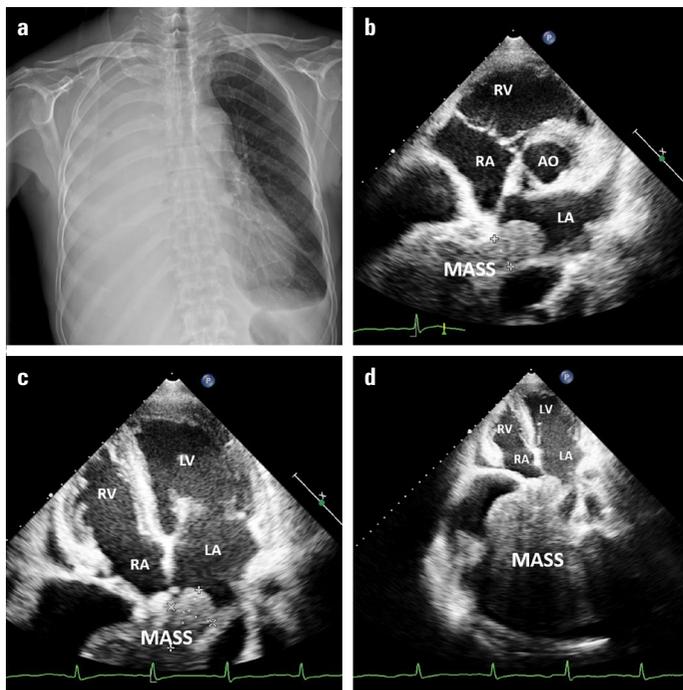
Chest X-ray revealing significant pleural effusion on the bilateral side with marked cardiomegaly (a). Transthoracic echocardiographic images showing the transfer of mass to the left atrium through the right inferior pulmonary vein at short axis view (b) and apical four-chamber view (c and d)
